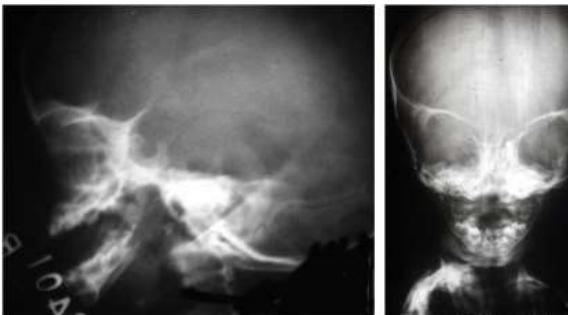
X-ray – Unilateral coronal suture ossification — Plagiocephaly
